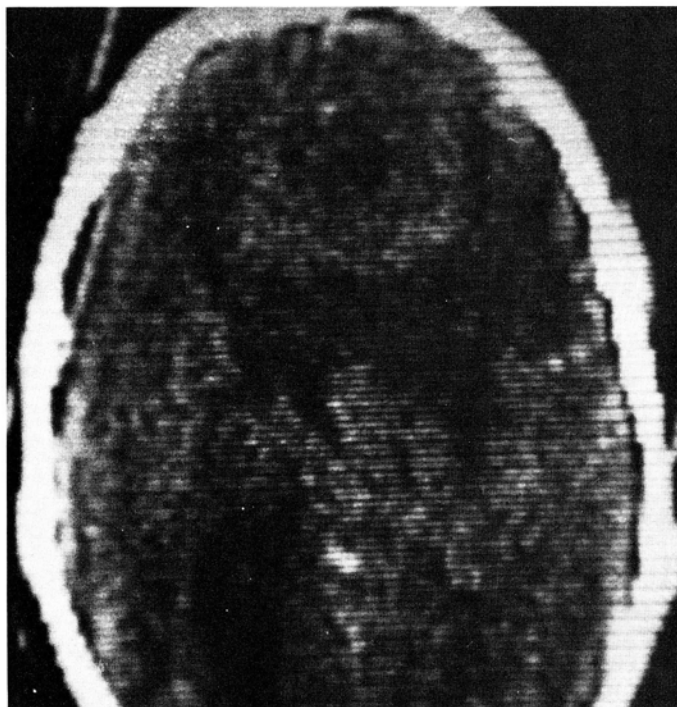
CT scan after injection of contrast material.
